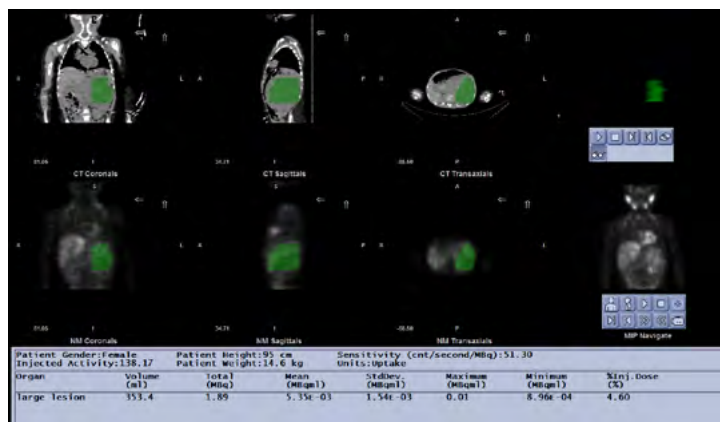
Quantitative SPECT screen directly showing activity concentration within regions of interest.
